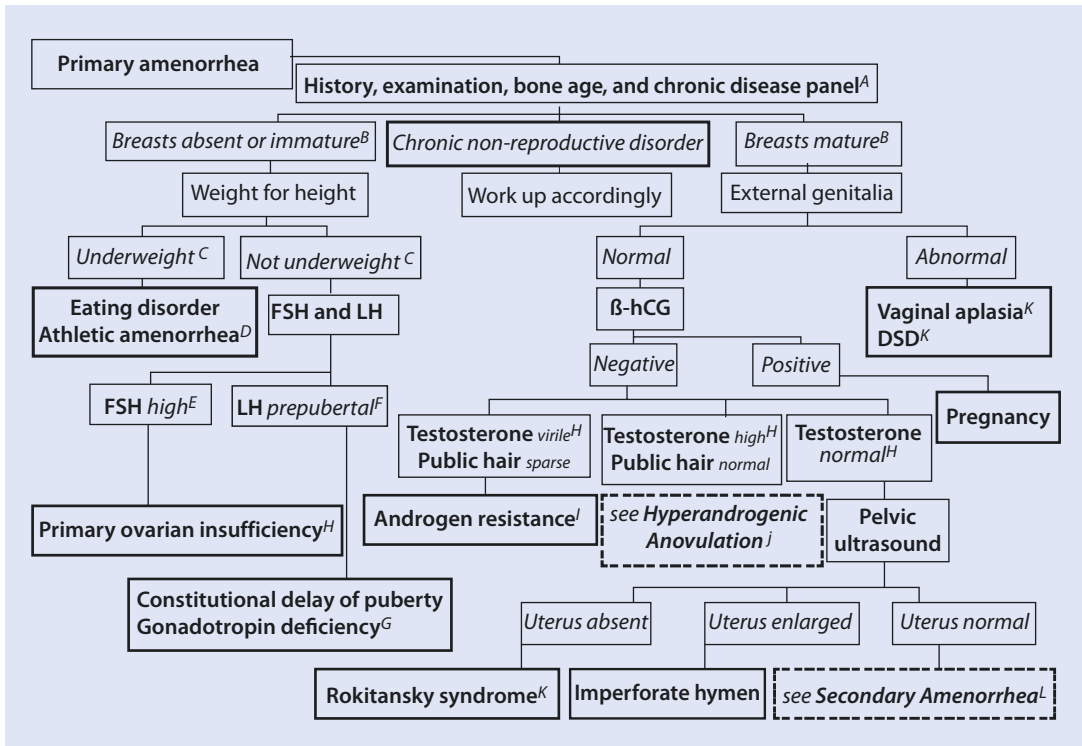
Differential diagnosis of primary amenorrhea (Modified from Rosenfield [9]). Footnotes: A. Prime among the causes of primary amenorrhea are growth-retarding or growth-attenuating disorders. In the absence of specific symptoms or signs to direct the workup, laboratory assessment for chronic disease includes bone age radiograph if the adolescent is not sexually mature and a complete blood count and differential, sedimentation rate, comprehensive metabolic panel, celiac panel, thyroid panel, cortisol and insulin-like growth factor-I levels, and urinalysis. B. Breast development ordinarily signifies the onset of pubertal feminization. However, mature breast development does not ensure ongoing pubertal estrogen secretion (see [Figs. 28.5 and 28.6](#)). C. BMI <10th percentile generally corresponds to body composition <20% body fat but does not accurately reflect body fat in serious athletes or in bulimia nervosa. D. Low body fat is associated with amenorrhea in underweight girls and from athletic activity out of proportion to caloric intake in overexercisers. E. FSH is preferentially elevated over LH in primary ovarian insufficiency (POI). The most common cause of primary amenorrhea due to POI is gonadal dysgenesis due to Turner syndrome, but acquired causes must be considered (such as cytotoxic therapy). The workup of POI is considered in detail in the next algorithm ([Fig. 28.5](#), secondary amenorrhea and oligomenorrhea). Lack of FSH elevation virtually rules out POI only when the bone age is appropriate for puberty (11 years or more). F. "Pediatric" gonadotropin assays sensitive to ≤ 0.15 U/L are critical to the accurate diagnosis of gonadotropin deficiency and delayed puberty. A low LH level is more characteristic of these disorders than
